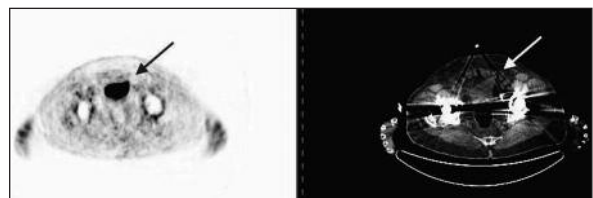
PET and CT images of inguinal region showing the angulation of bladder into the left inguinal canal (note the metal artifacts of bilateral hip prosthesis).
